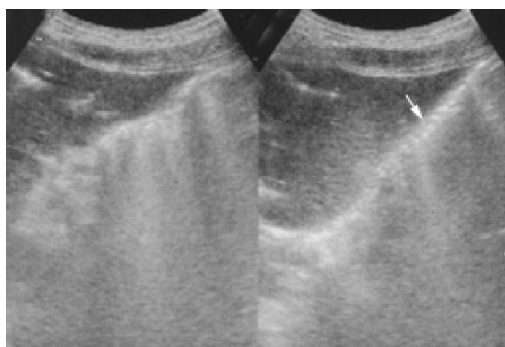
Abdominal sonography showing air in the gastric wall (arrow).
